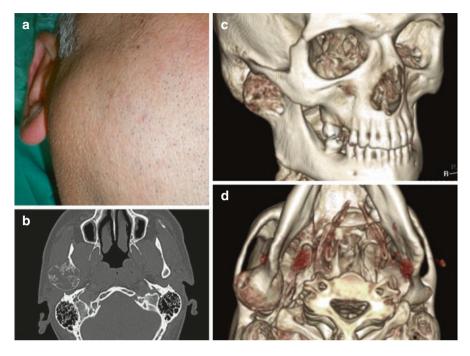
Case 5. (a) A 42-year-old male presented with a right preauricular tumor, (b–d) CT scan imaging demonstrated an expansive osteolytic tumor located in the right mandibular condyle. Biopsy under local anesthesia demonstrated a fibrous benign tumor
